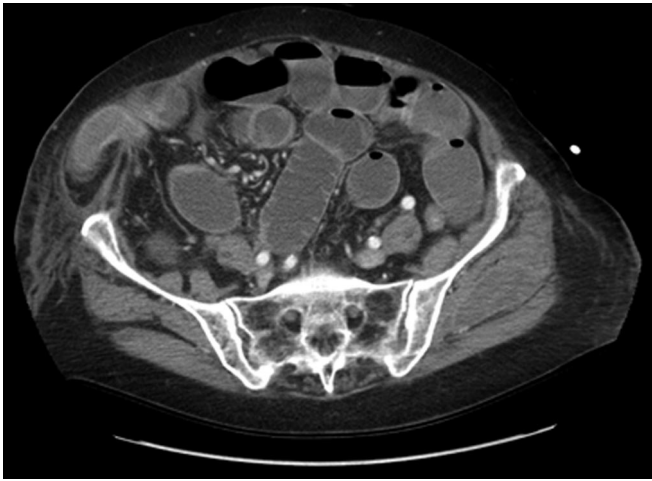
CT Scan image revealing right sided Spigelian hernia.
